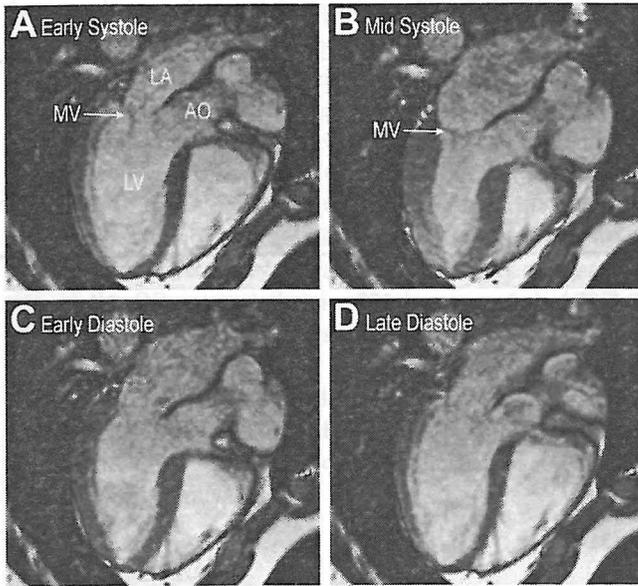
Four still frames from two-chamber MRI movie of a beating human heart. Left atrium (LA), left ventricle (LV), aorta (AO), and mitral valves (MV) are indicated. A: Early systole. B: Mid-systolic frame. C: Early diastole (E in Figure 5). D: Late diastole (A in Figure 5). See text for details.
